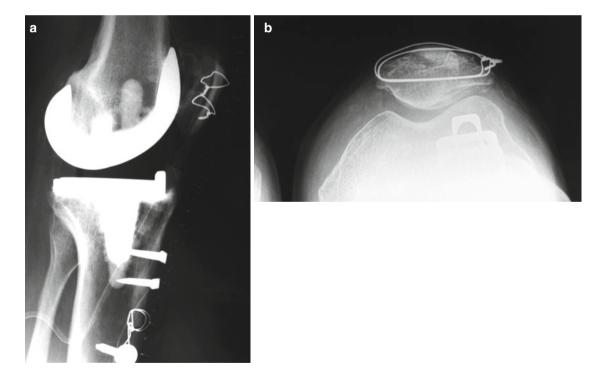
Postoperative lateral (a) and axial (b) x-rays
